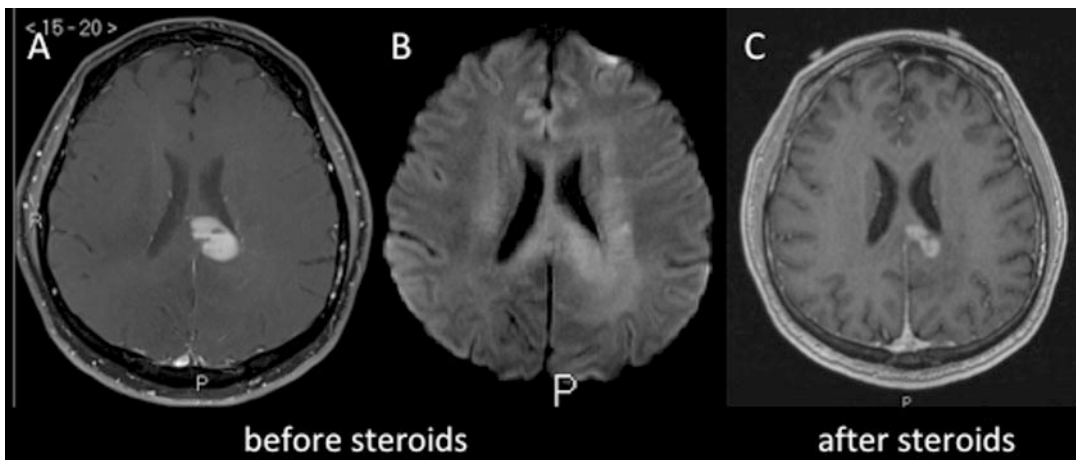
T1w + Gad and DWI images before (a, b) versus T1w + Gad images after (c) steroid administration in a middle-aged male with suspected primary CNS
